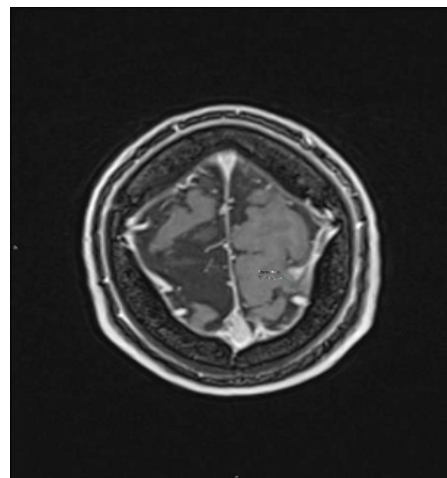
MR of cerebrum December 2019. Showing progressive regression of the abscess compared to the initial MRI scanning (lesion diameter 5,0 mm).
